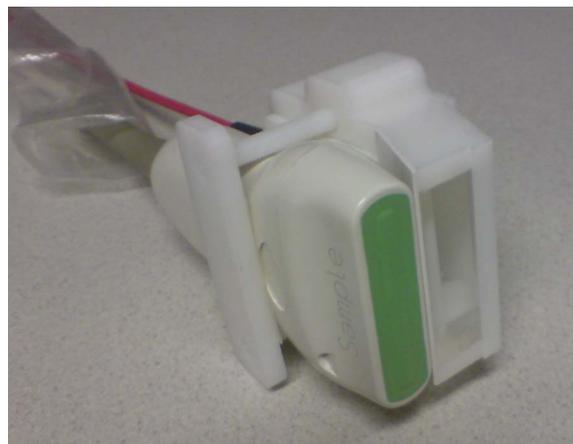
Optical system attached to an existing ultrasound probe.
